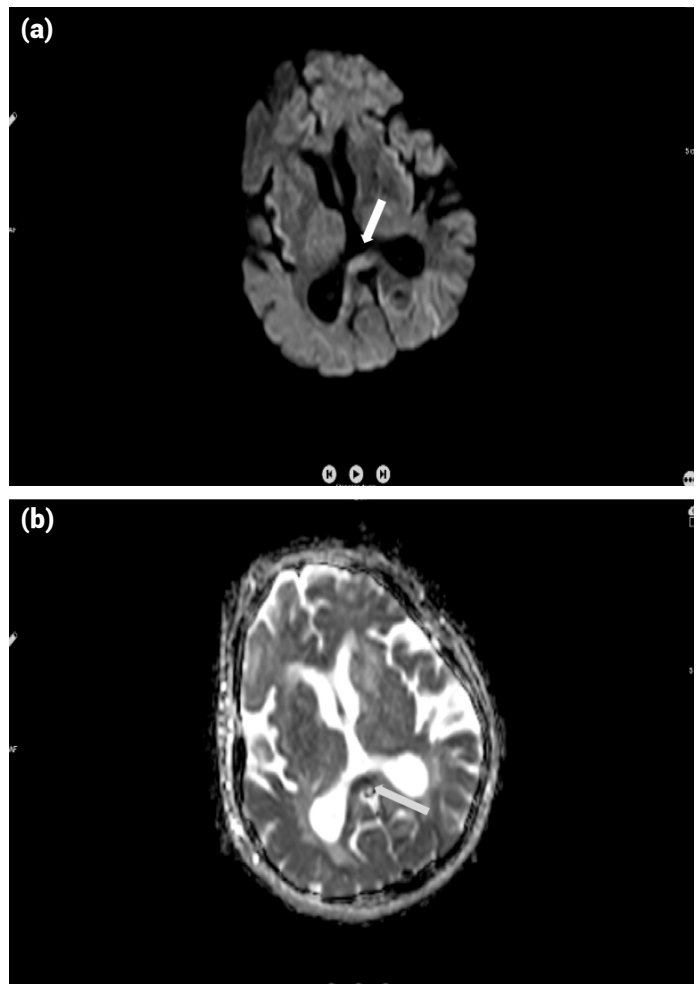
Case 4: (a) Acute diffusion restriction in the splenium of the corpus callosum on diffusion MRI; (b) Hypointense lesion was showed by an arrow on ADC.r54esw.
